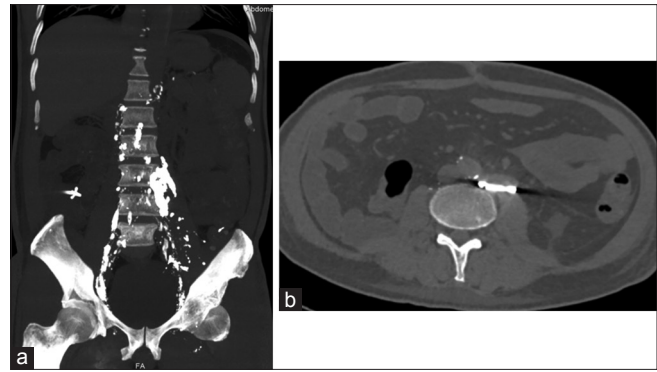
(a) Computed tomography abdomen multiplanar reformat demonstrating dense pooling of lipiodol at the site of chyle leak; (b) Axial section showing chyle leak in the left para-aortic region
